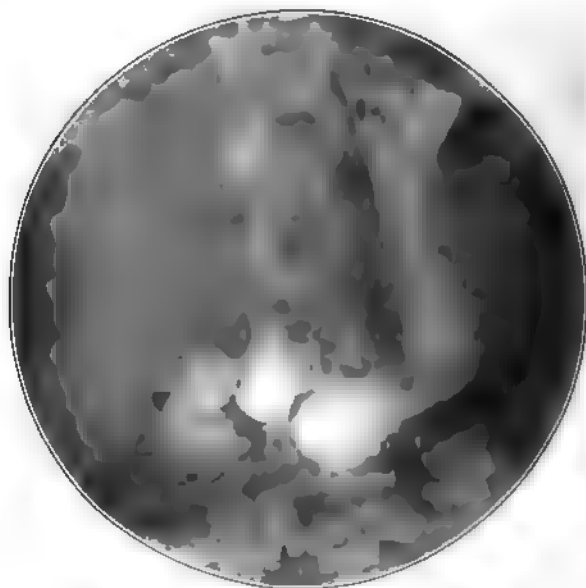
(58,949.) Second examination August 31, 1914. No retention from the six-hour meal. Pyrosis gaping. Narrowing of the pars media and cardiaca. Roentgen diagnosis: Lesion of the stomach. Achylia. Wassermann persistently positive after repeated intravenous injections of salvarsan, but there was marked general improvement by November, 1915.
